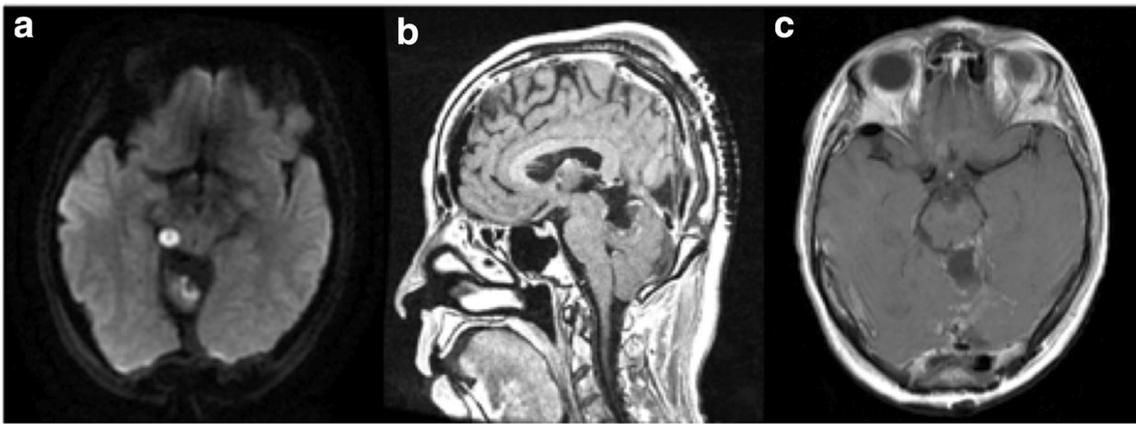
Postoperative MRI imaging. a DWI axial cut showing minimal residual of the epidermoid cyst at the right quadrigeminal plate. b, c Post contrast studies sagittal and coronal respectively showing gross total resection of the squamous cell carcinoma
